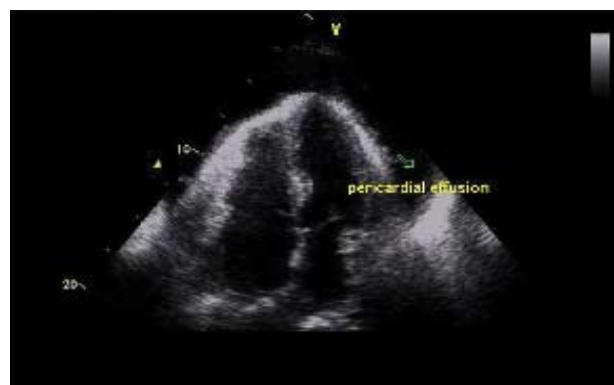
Echocardiogram showing massive pericardial effusion surrounding the anterior and lateral wall.
